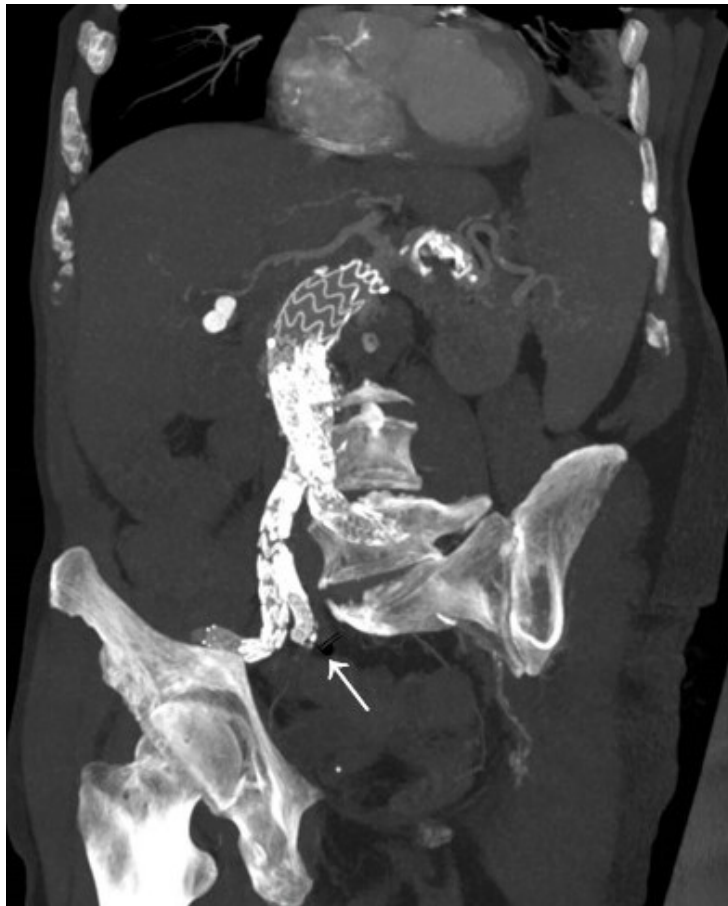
One-month postoperative CT angiography showing us correct implantation and good patency of the iliac extensions and hypogastric branch (white arrow).
